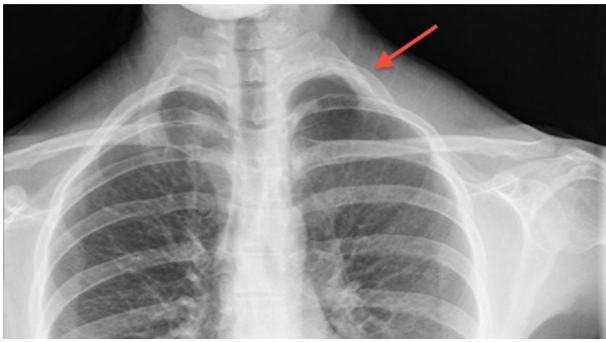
Apical-lordotic chest radiograph indicating asymmetry of the left first and second thoracic ribs and elevation of the second rib (arrow).
